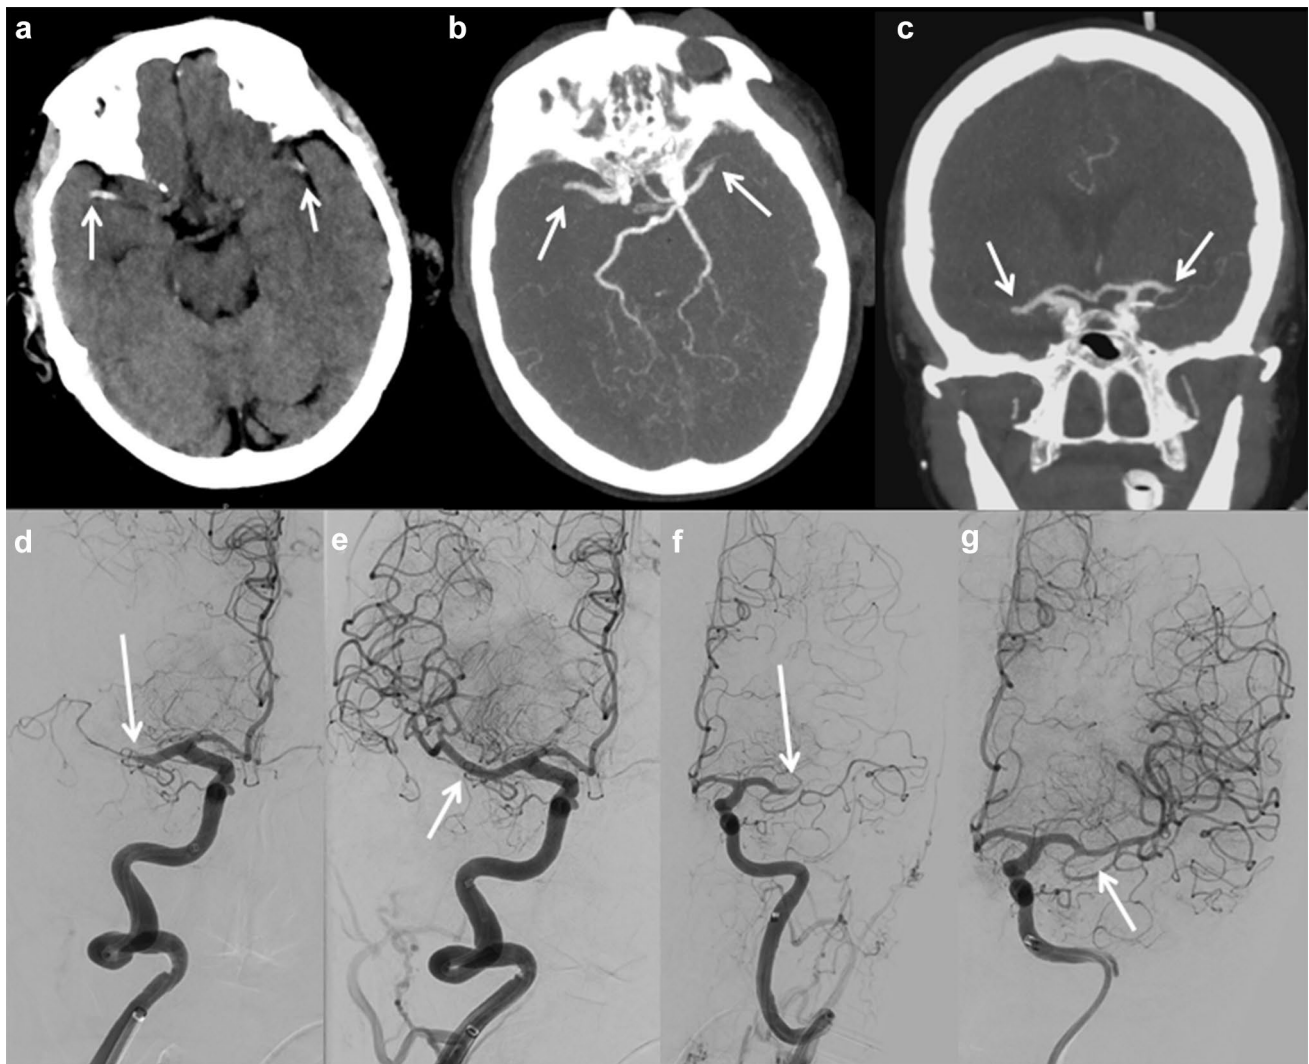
Nonenhanced brain CT showed bilateral hyperdense MCA (a arrows) with no apparent ischemic changes. Acute bilateral focal occlusion of M1 segments is confirmed by CT angiography (b, c arrows). Right (d) and left (f) M1 occlusion (arrows) demonstrated
